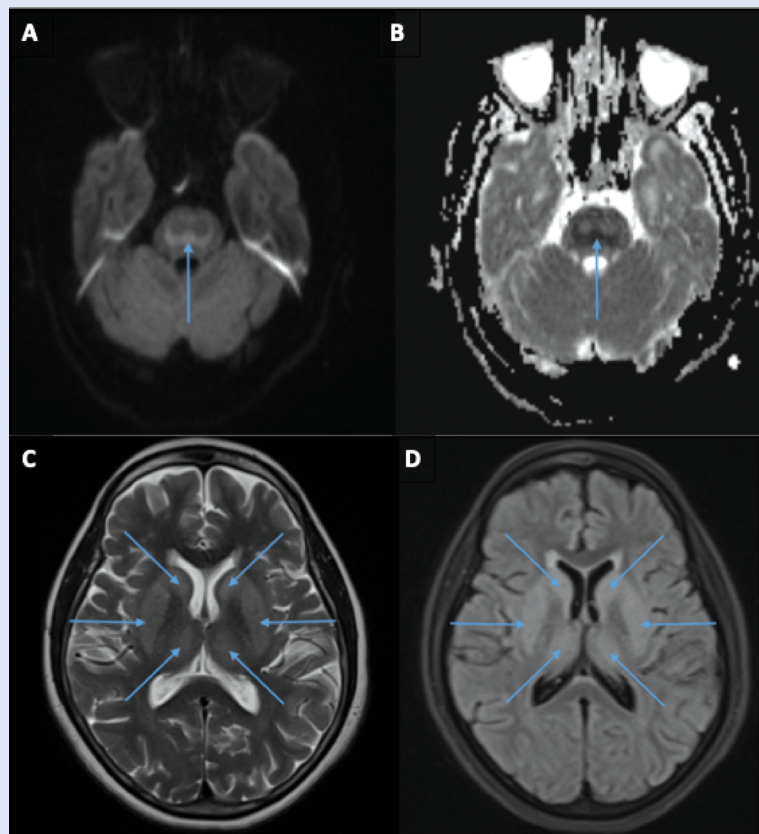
MRI Brain showing central pontine and extrapontine myelinolysis. Panel A: DWI sequence with high signal intensity and Panel B: Corresponding ADC image showing low signal intensity suggestive of diffusion restriction at the level of pons, typical of “trident sign” (Arrows). Panel C: T2 weighted sequence and Panel D: FLAIR sequence showing symmetrical high signal intensities in bilateral head of caudate nuclei, lentiform nuclei and thalamus (Arrows) suggestive of extrapontine myelinolysis.
